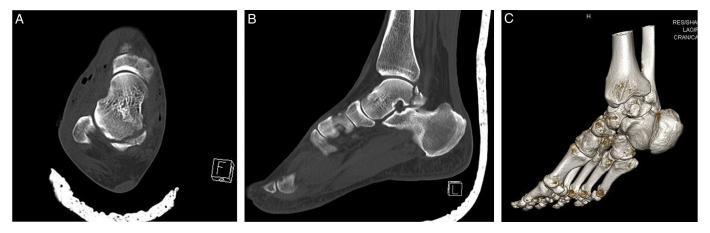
(A) Axial, (B) sagittal, and (C) 3D reconstruction images of computed tomography scan taken after closed reduction of the subtalar dislocation showing a comminuted fracture of the posterior process of the talus.
